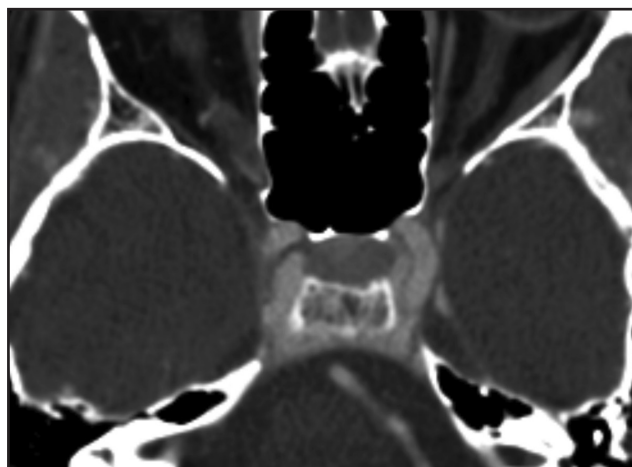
Axial postcontrast CT through the same level at the clivus demonstrates enhancing soft tissue dorsal to the clivus similar to the remainder of the vasculature.
